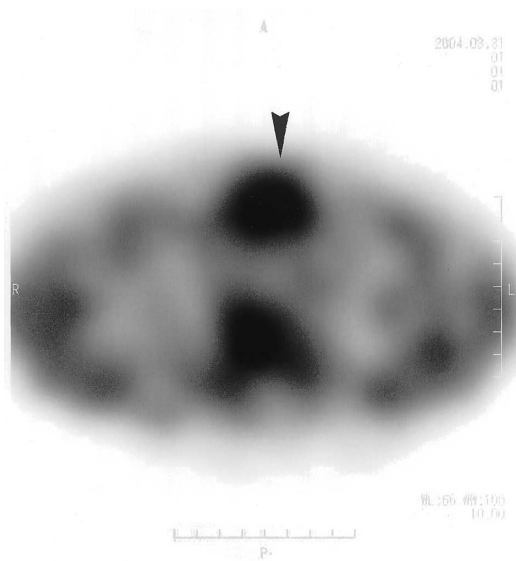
Obvious thallium-201 accumulation in the thymus was seen on delayed phase SPECT.
